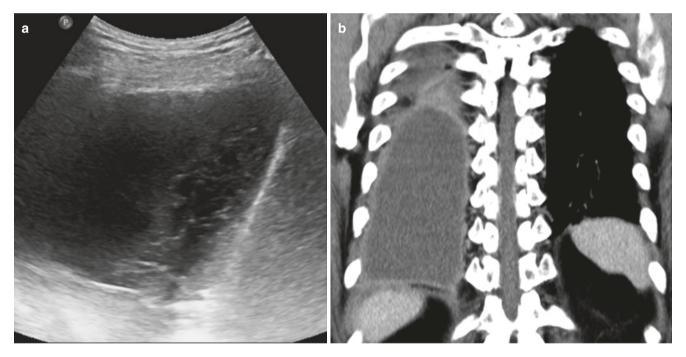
Empyema. (a) Bedside ultrasound examination in a patient with pneumonia demonstrates moderate right pleural effusion with irregular echogenic strands (honeycomb appearance). (b) Coronal CT
